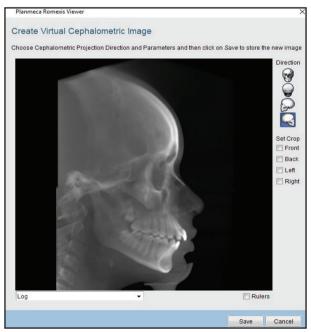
Extracting lateral cephalometric radiograph from CBCT scan using Romexis software
